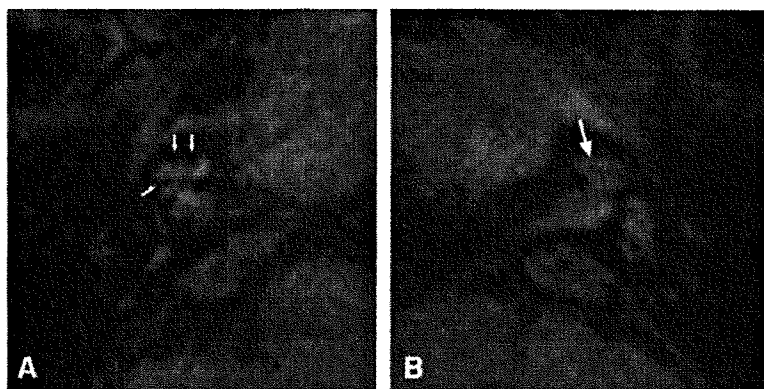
3D-FLAIR MRI of case 3. A, right ear; B, left ear. In A, short arrows indicate endolymphatic hydrops in the basal and upper turns of the cochlea (wedge-like areas). In B, the cochlea shown by an arrow has no hydrops.
